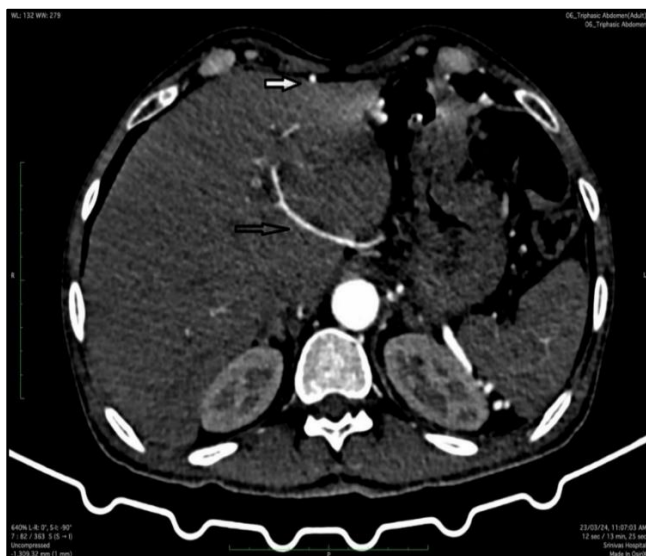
CT Abdominal Angiogram Shows the Collateral Supply (Black Arrow) of the Left Hepatic Lobe from a Prominent Right Internal Thoracic Artery (White Arrow)
